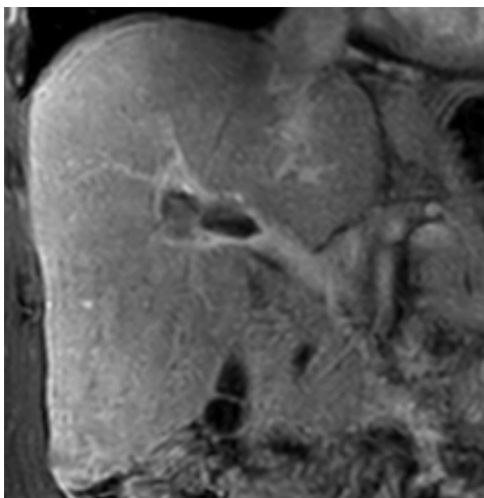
Filling defect in the right portal vein, coronal LAVA magnetic resonance imaging sequence.
